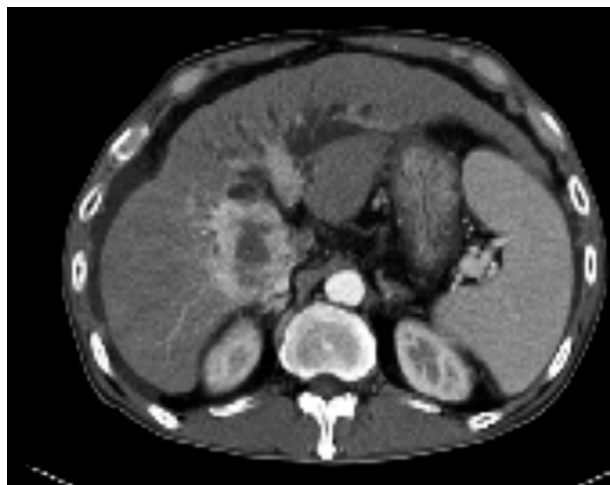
Abdominal computed tomography scan showing a 5.6 \times 5-cm-sized arterial and portal enhancing, delayed-washout mass with a central necrotic portion in segment 1. It is likely that intrahepatic bile duct dilatation and right portal vein and hilar invasion are also present. Underlying liver cirrhosis with splenomegaly and ascites is also present.
